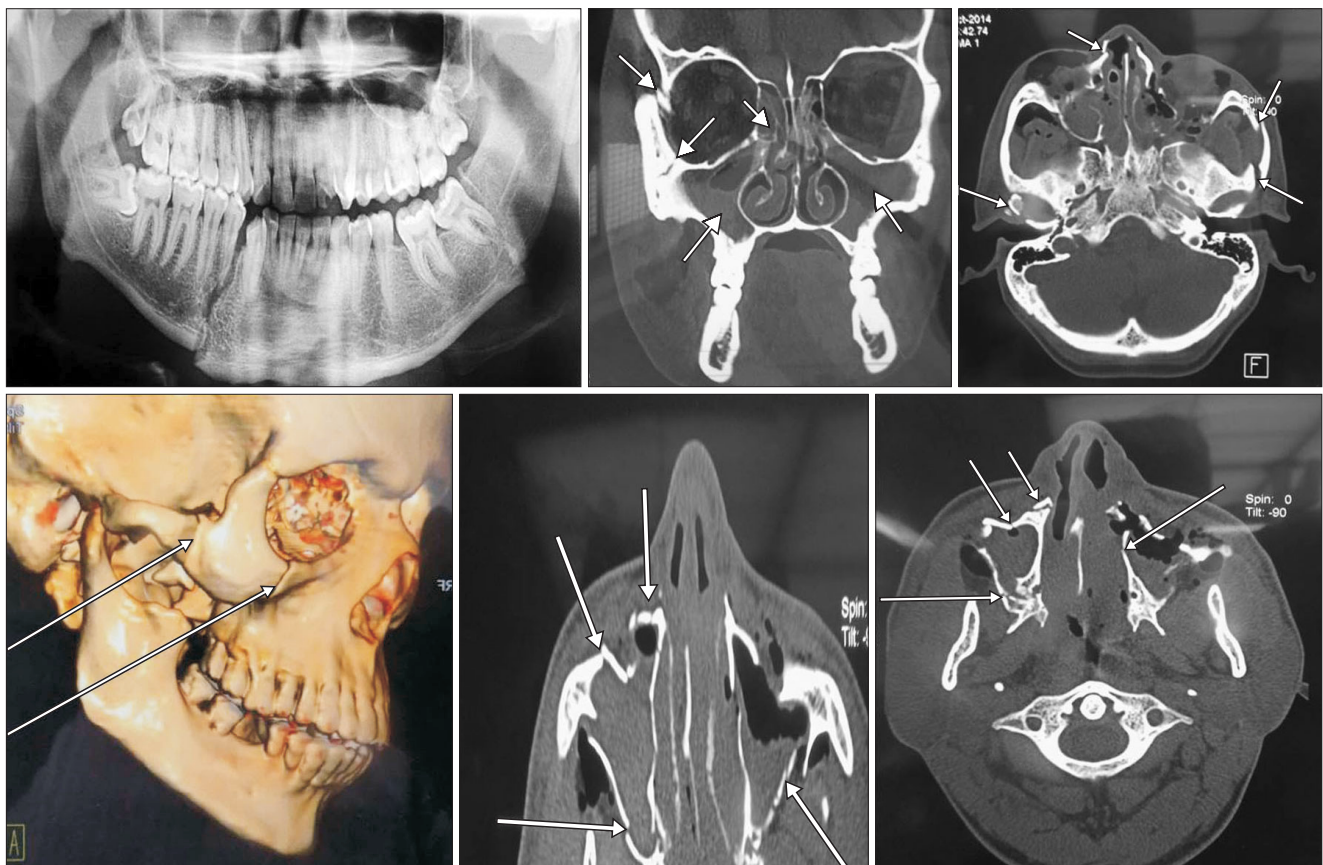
Patients orthopantomography and computed tomography of maxillofacial injuries (arrows).
